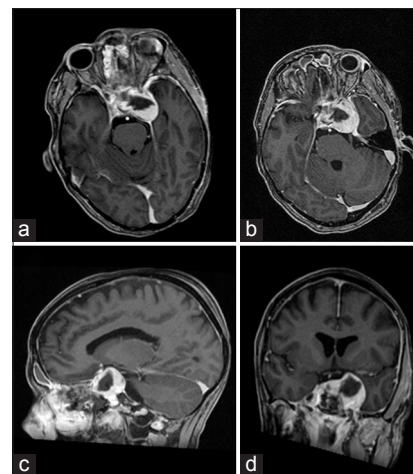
Immediate postoperative imaging after endoscopic tumor debulking. Axial (a and b), sagittal (c), and coronal (d) T1 magnetic resonance imaging with gadolinium depicting residual tumor in the left cavernous sinus with expected postoperative changes
